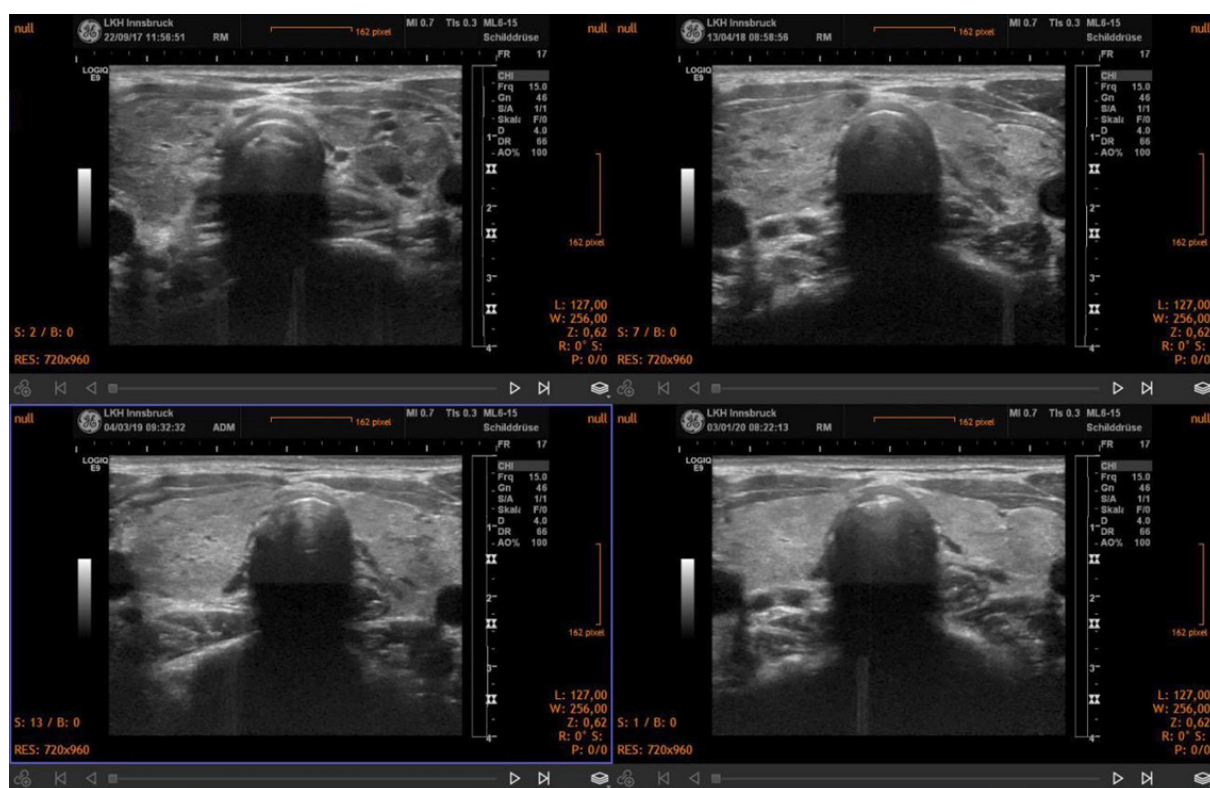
B-mode sonography showing improved morphology
